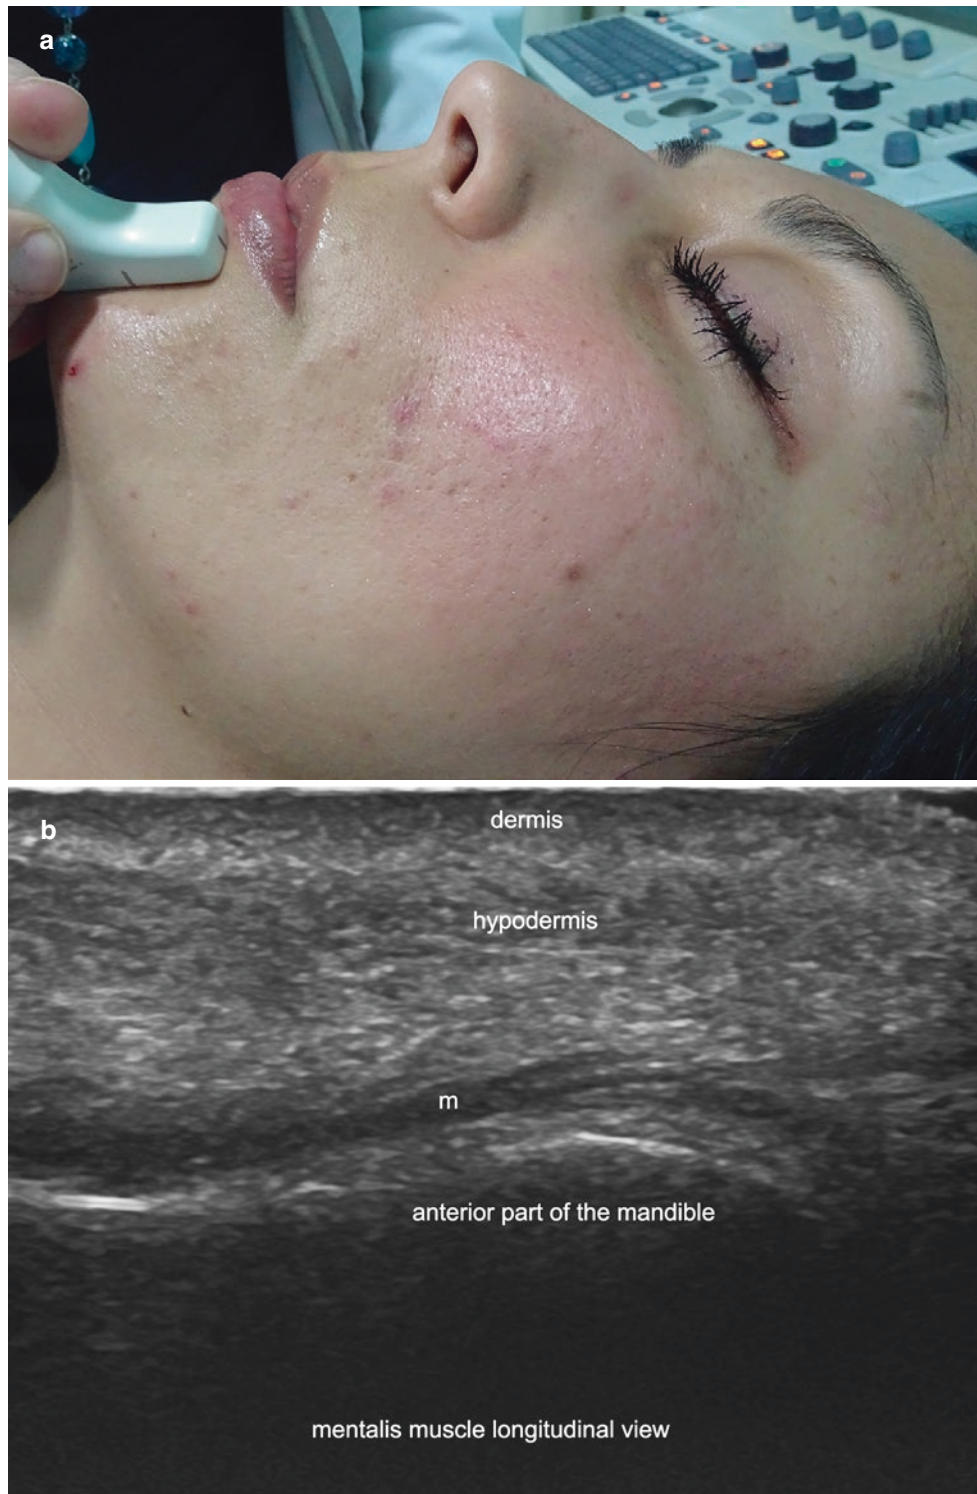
Mentalis muscle. (a) Clinical image shows the location of the probe. (b) Ultrasound (longitudinal oblique view) shows the hypoechoic band of the left band of the mentalis muscle (m) attached to the anterior aspect of the mandible.
